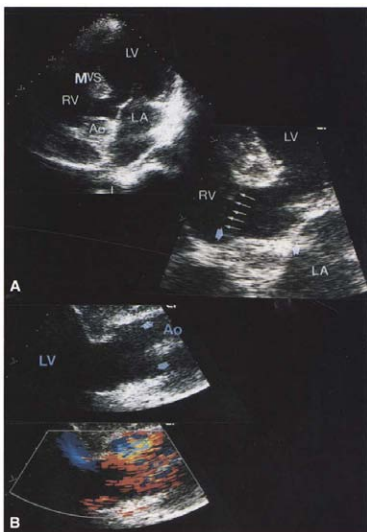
A, Apical five-chamber view at left demonstrates malalignment of the muscular (M) and membranous ventricular septum (VS). At right, magnification of the left ventricular (LV) outflow tract shows a huge membranous septum (26 mm, small arrows) inserting not on the crest of the muscular ventricular septum but on the right ventricular side. B, This causes the muscular septum to protrude into the outflow tract without causing an obstruction (parasternal long-axis, view top). However, the systolic color flow map (bottom) shows turbulence in the region where the surgeon had previously resected a subvalvular aortic stenosis. Large arrowheads = aortic valve anulus. RV = right ventricle; other abbreviations as in Figure 1.
